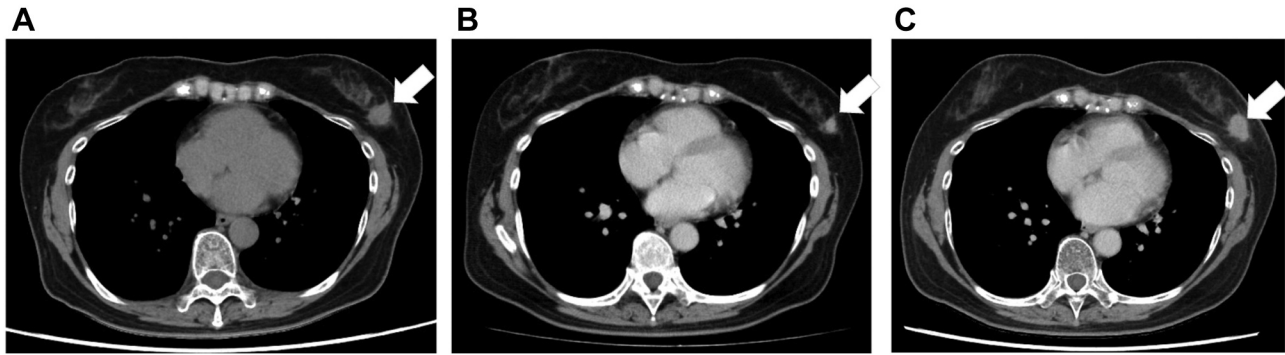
Computed tomography imaging during neoadjuvant chemotherapy (NAC). A) Before treatment with NAC, a 16 mm mass in the left breast (white arrows) was identified. B) After treatment with epirubicin and cyclophosphamide, the tumor shrank (white arrows). C) After treatment with docetaxel, regrowth of tumor was observed (white arrows).
